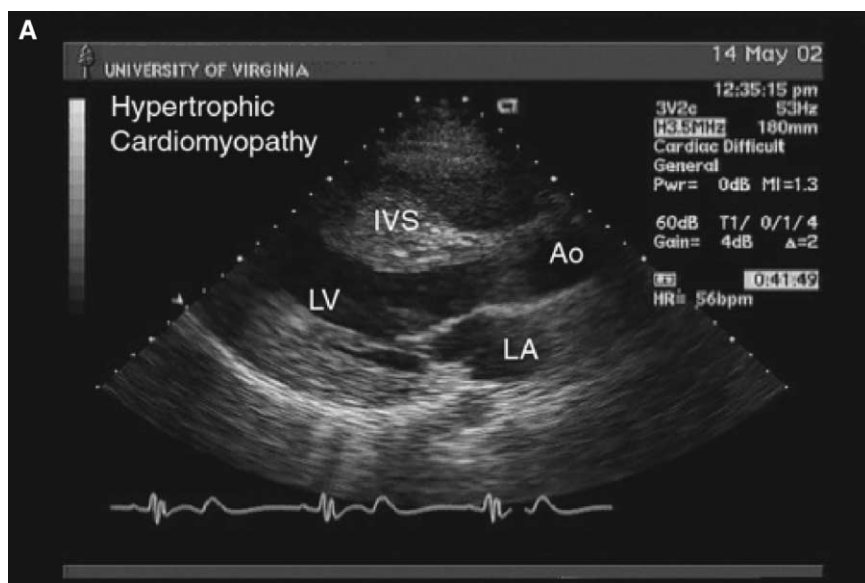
(A) Two-dimensional parasternal echocardiogram of a patient with hypertrophic cardiomyopathy. Note the markedly thickened interventricular septum (IVS), which measured over 2 cm (normal septal thickness is 0.5–1.0 cm). (B) Two-dimensional apical echocardiogram of the same patient with HCM. The entire left ventricle is thickened, with a small cavity; in some patients; the thickening is most pronounced in the septum, whereas in others, the wall thickening is diffuse. (C) Doppler echocardiogram in a patient with HCM and dynamic outflow tract obstruction; the characteristic saber-shaped signal is indicative of a gradient that increases during systole. Using the Bernoulli equation, this patient’s outflow gradient was measured at a peak of 64 mm Hg, indicative of severe obstruction. This patient would be ineligible for competitive sports.
